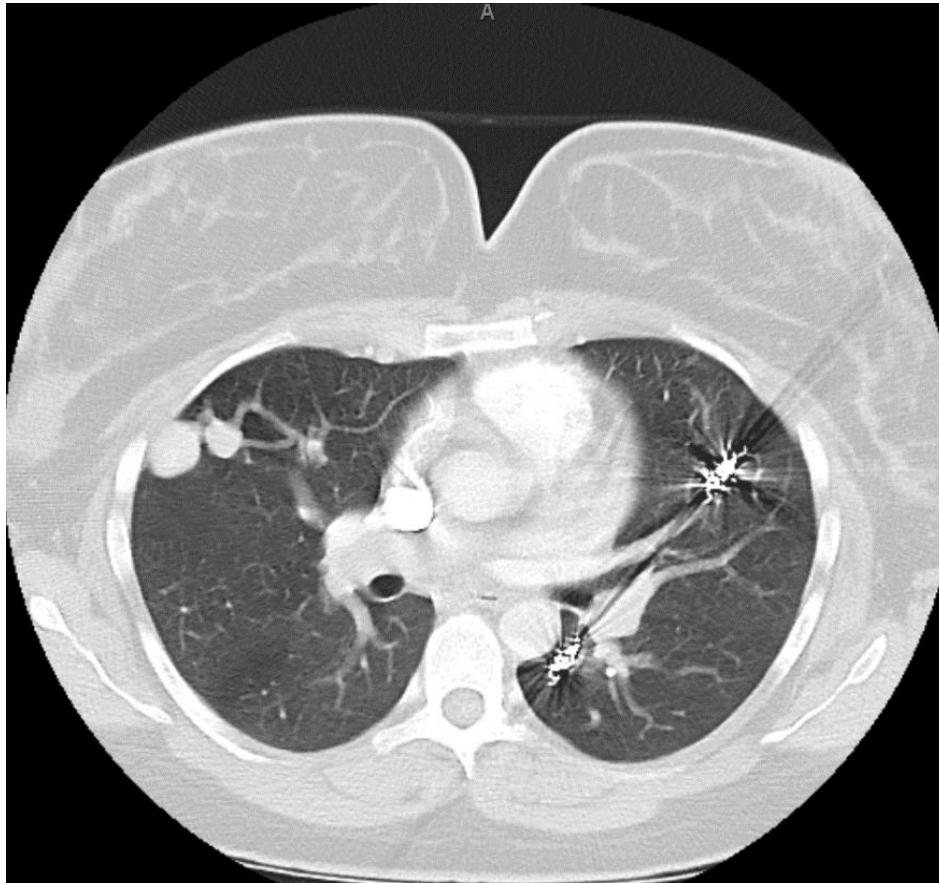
Computed tomography scan of chest demonstrating coil placement during third trimester of pregnancy.
